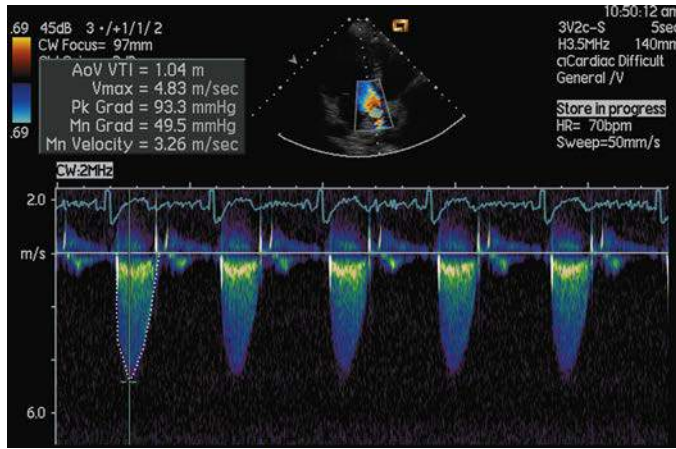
Doppler evaluation of a stenotic bicuspid aortic valve.
